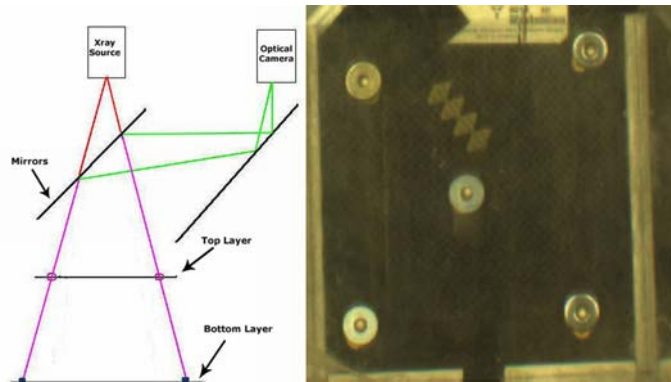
(Left) The markers on the bottom layer can be seen through the rings on the top layer if the X-ray source (source of red beams) and the optical camera center (source of green beams) are virtually aligned (pink beams). (Right) The alignment of five pairs of markers and rings in the video image.
